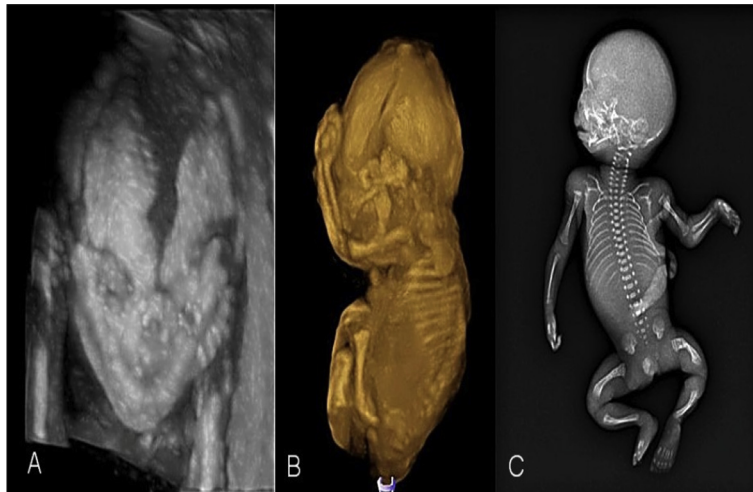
Case 4. (A) Transabdominal two-dimensional ultrasound performed at 21⁺³ weeks documenting a wide metopic suture associated with micrognathia. (B) Three-dimensional ultrasound reconstruction using surface minimum mode showed an extremely bent femur at diaphysis level. (C). Radiography confirmed ultrasound images and disclosed splaying of the transverse vertebral processes in the cervical spine. Maxillary and mandible bone hypoplasia, and bent femora were also identified at *post mortem* examination.
